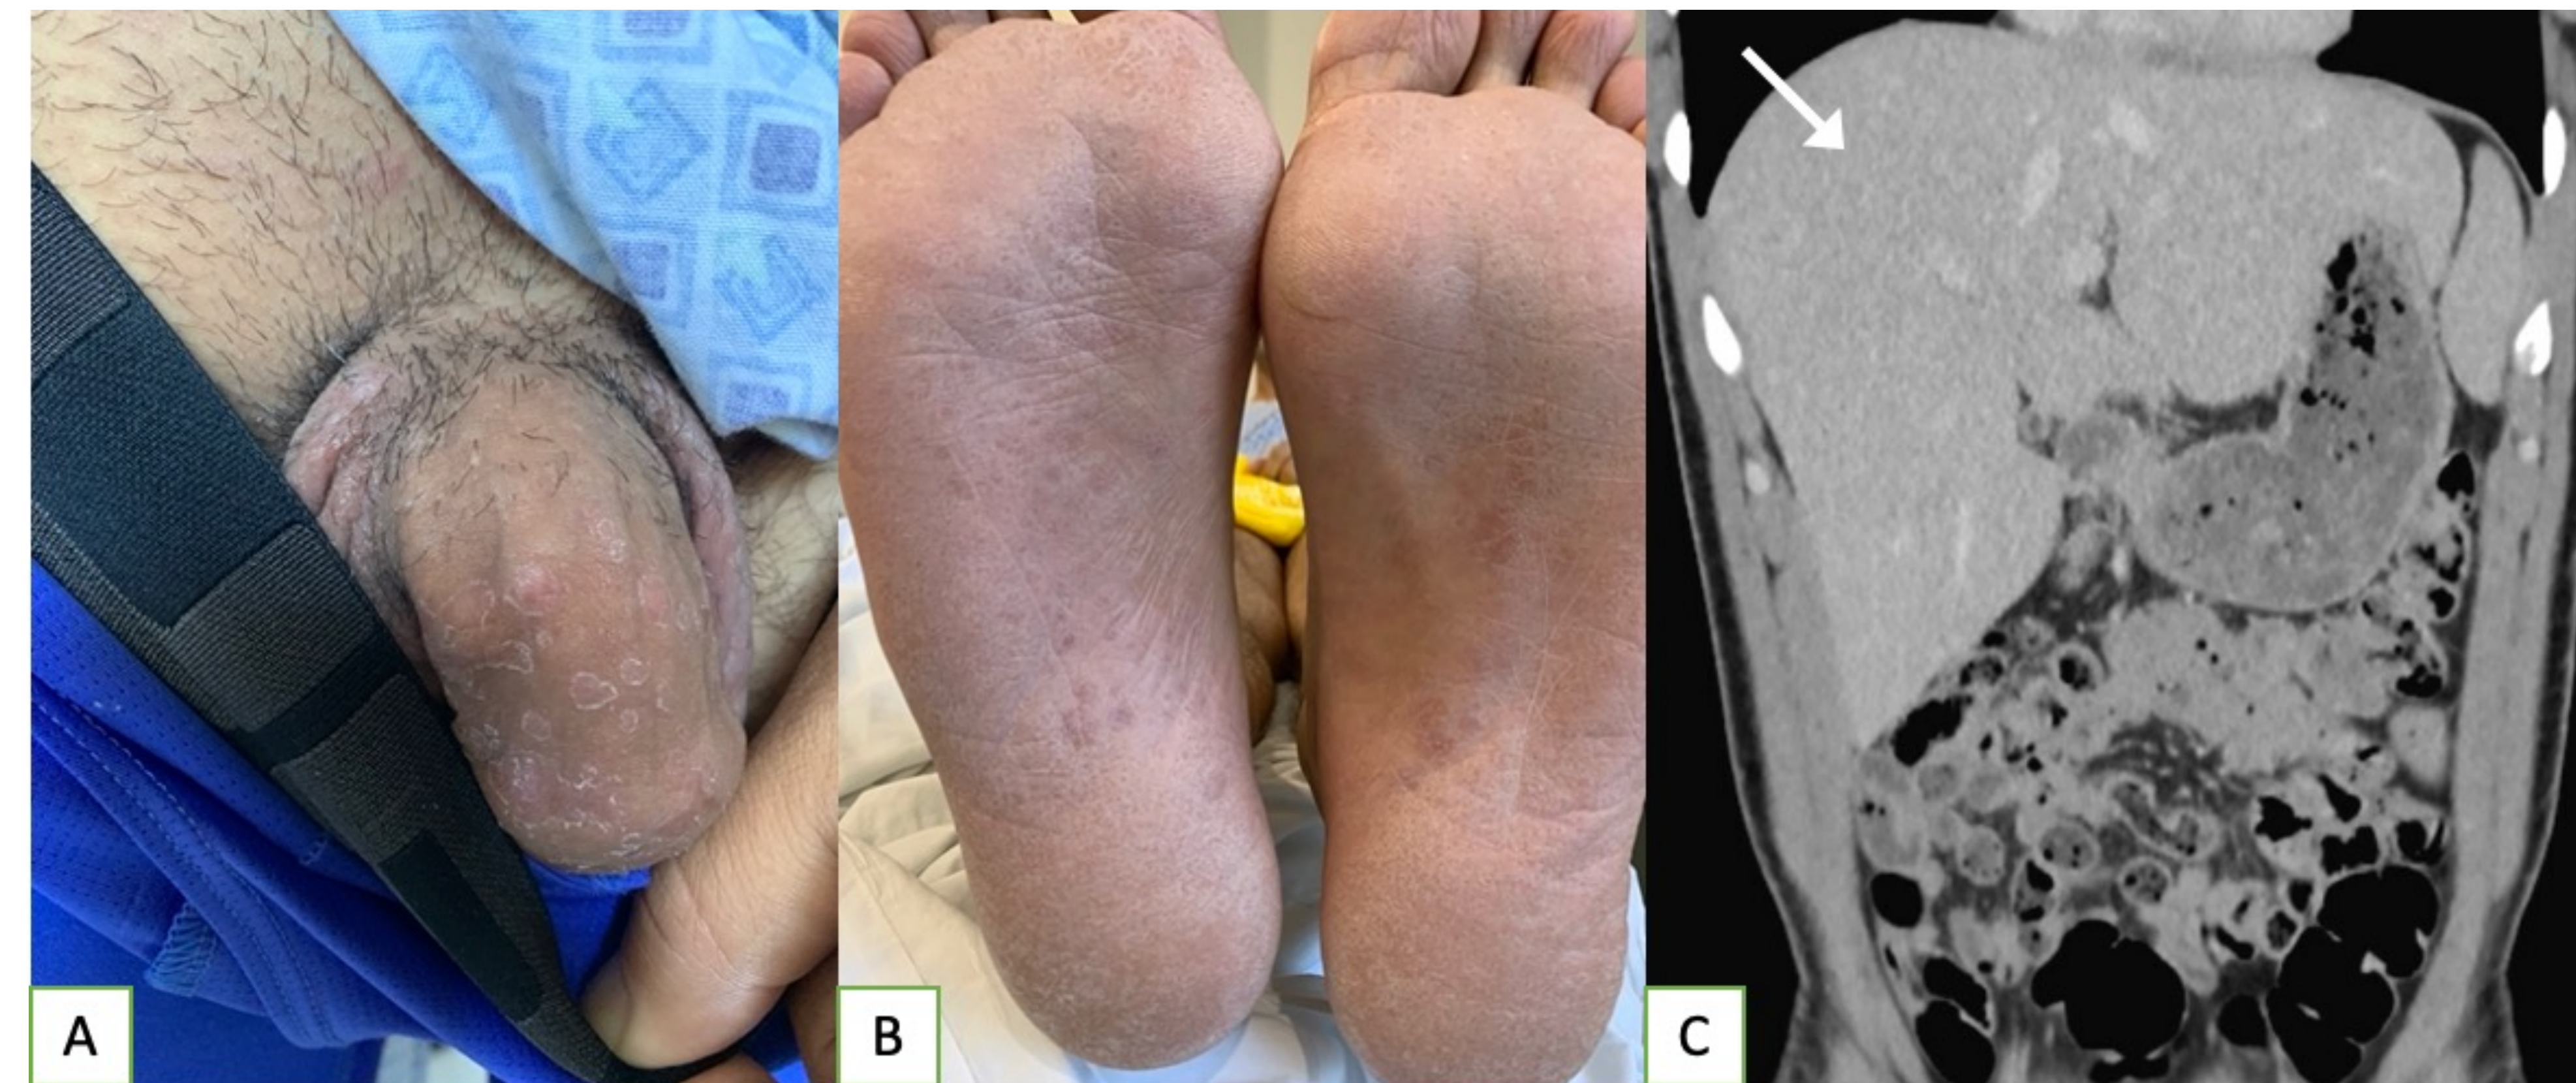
A. Papulosquamous rash of the penile shaft B. Resolving hyperpigmented papulosquamous rash involving the soles of bilateral feet C. CT abdomen with contrast (coronal view) demonstrating hepatomegaly, liver (arrow) measuring 20.2cm
